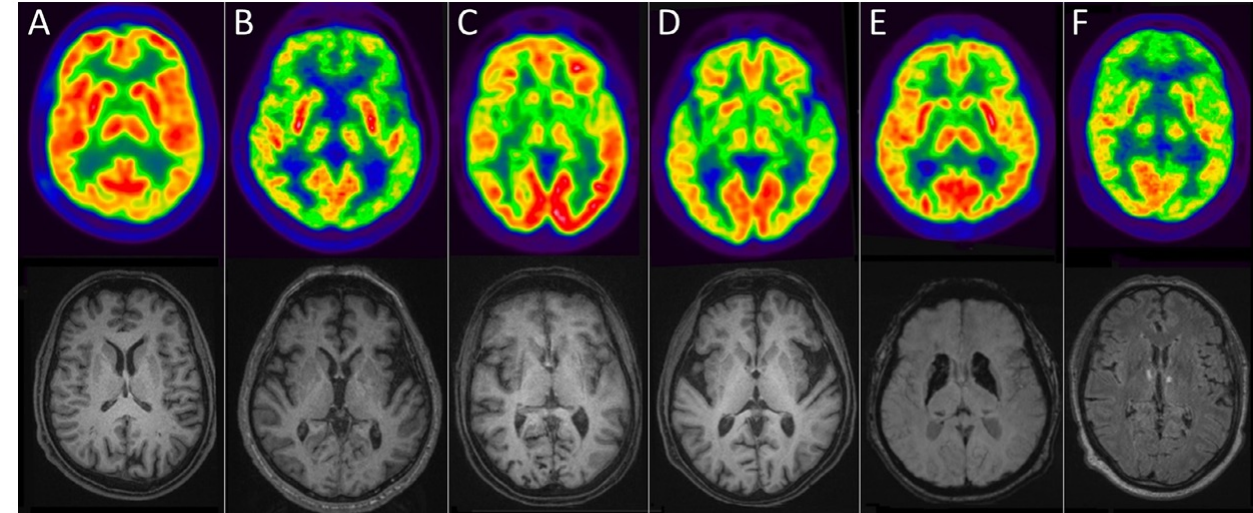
A number of ^{18}F -FDG PET/MR cases showing striatal hypometabolism (upper row) in different conditions. (A) healthy control (to be used as reference), (B) progressive supranuclear palsy, (C) multiple system atrophy with predominant parkinsonism, (D) Huntington disease, (E) FAHR's disease and (F) thalamic bilateral lacunar infarct. On the lower row corresponding anatomic images: T1 isotropic MPRAGE (A-D), Susceptibility-Weighted Imaging (SWI) (E) and T2-Flair (F).
